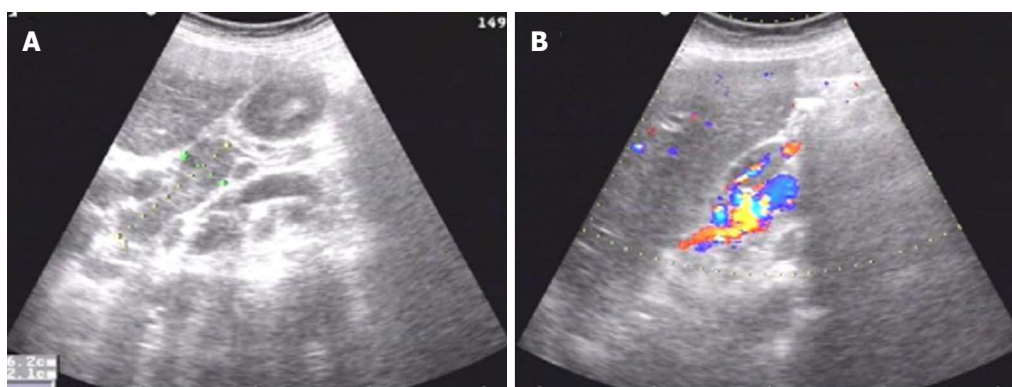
Ultrasound endoscopy showed cholecystitis and several enlarged abdominal lymph nodes. A: The enlarged lymph nodes were found in the porta; the lymph nodes showed a syncretic image with a clear boundary and uniform echo; B: A rich blood flow signal was observed in the lymph nodes.
